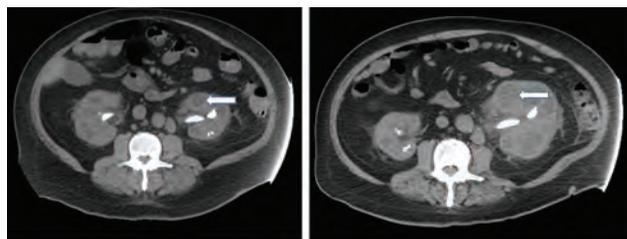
Abdominal CT- 10 months prior (left): bilateral staghorn calculi with rounded areas of low-attenuation replacing renal parenchyma representing “bear paw” signs (white arrows). Present (right): interval enlargement of left kidney with larger low-attenuating spaces consistent with worsened XGP; smaller right kidney with less stone burden.
